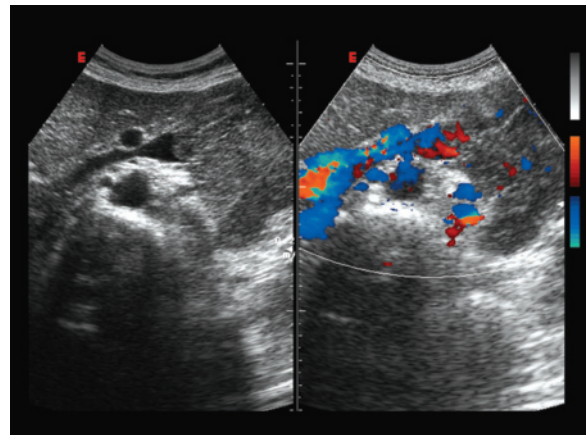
b Pancreatic carcinoma invading the vessels. Solid mass of the body of the pancreas seen encircling the splenic artery, site of aliasing artifacts (a). Spectral Doppler of the stenotic artery (b) identifies very high systolic peak velocities (>400 cm/s)
